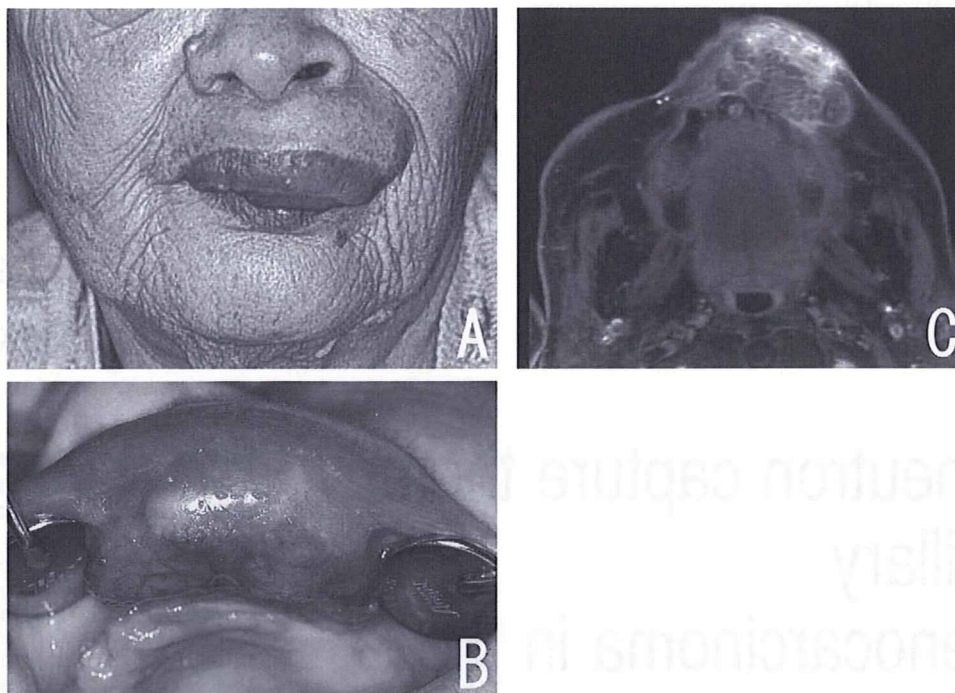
(A, B) A large tumor mass that induced pain and difficulty in eating was seen in the left upper lip. (C) MRI (Gd-enhanced fat-suppressed image) revealed a large space-occupying mass lesion located in the left upper lip.
